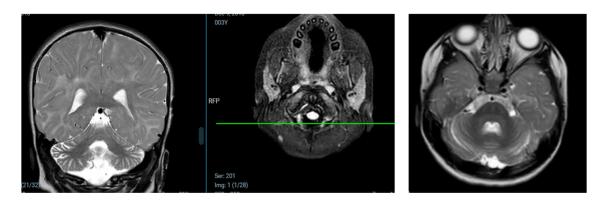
Brain MRI shows mild cerebellar atrophy and delayed myelinations
